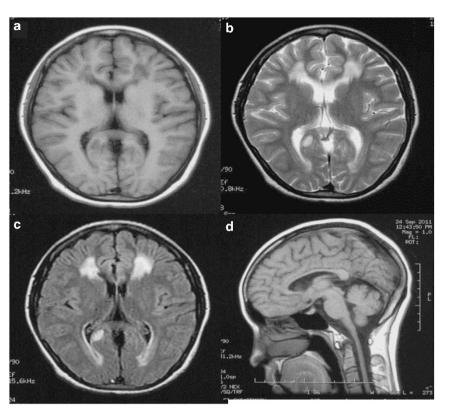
The brain magnetic resonance imaging of the presymptomatic mother with type II AxD. (a) (T1 image), (b) (T2 image) and (c) (Flair image) showed abnormalities in periventricular white matter, and atrophy of the medulla oblongata and upper cervical spinal cord (d).
